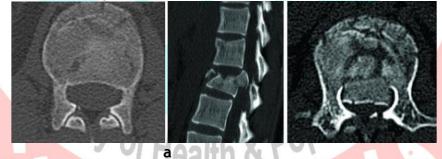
CT fracture lumbar spine with free neural canal (a) and bone fragment present in the neural canal (b)
